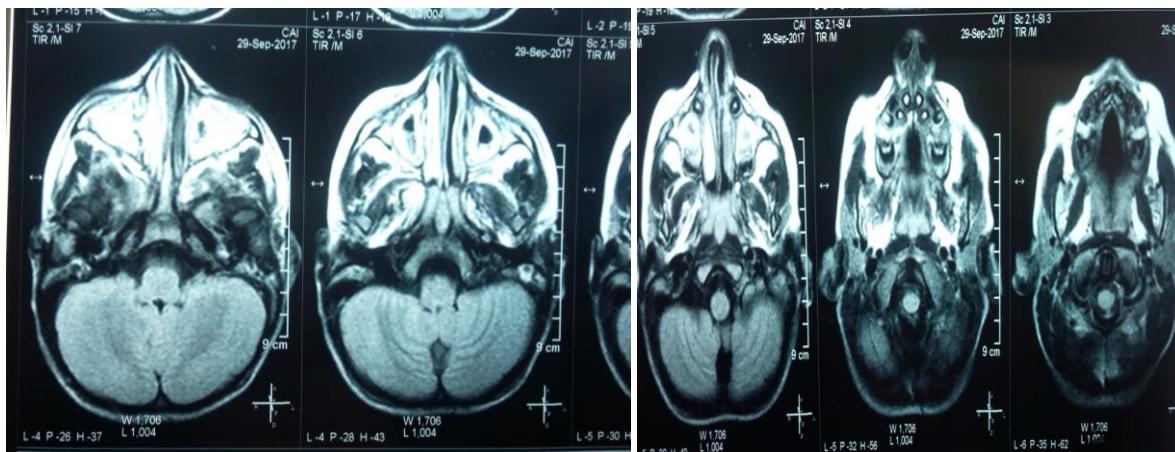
MRI images in axial sections with gadolinium injection in T2 sequence showing the different site malformations
